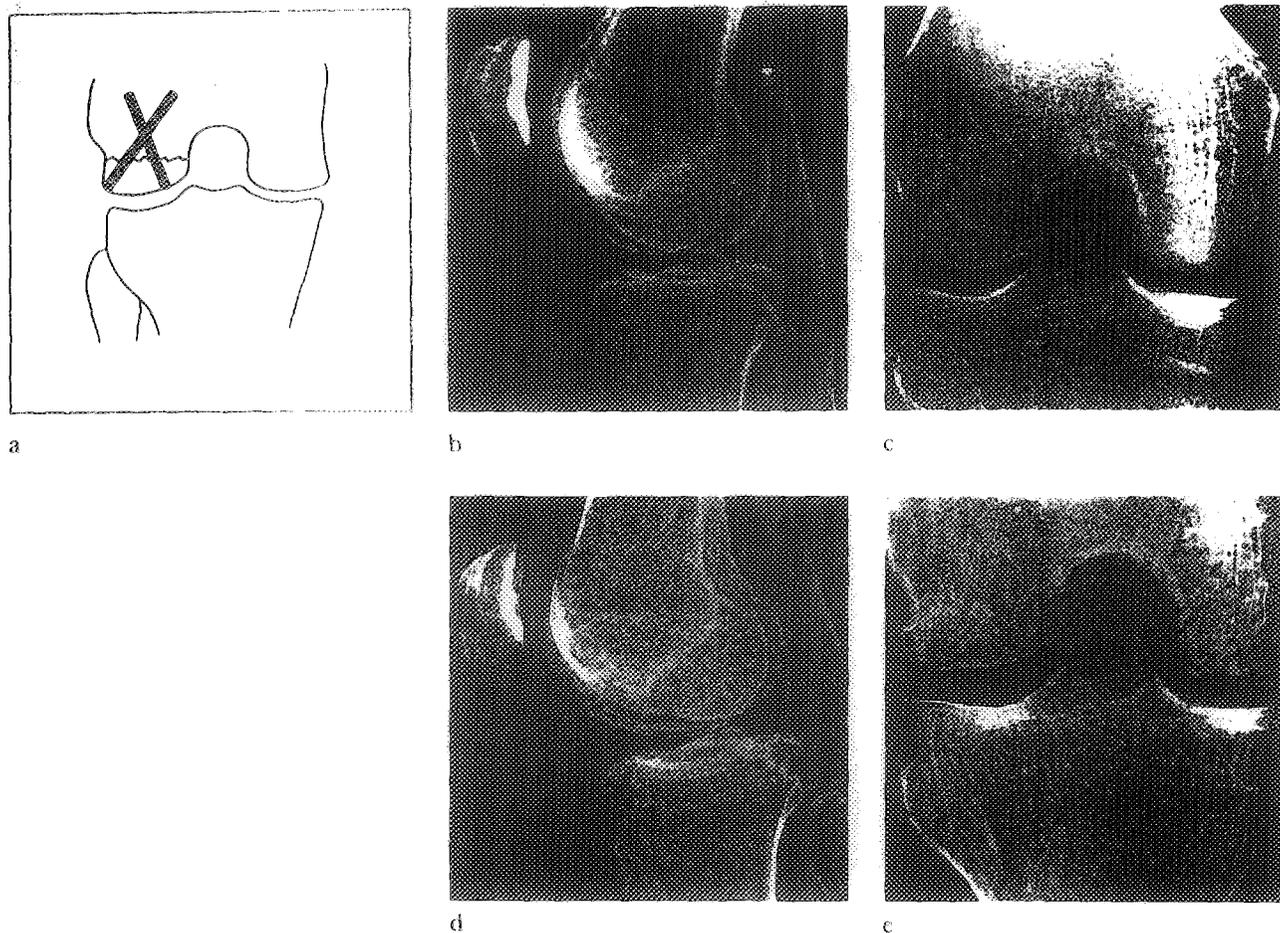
Fixation of fracture of the femoral condyle (a). Radiograph of a displaced fracture of the lateral condyle of the femur in lateral view and in tunnel view on admission (b-c) and three months after fixation with two 3.2 by 50 mm BIOFIX®-rods (d-e).
